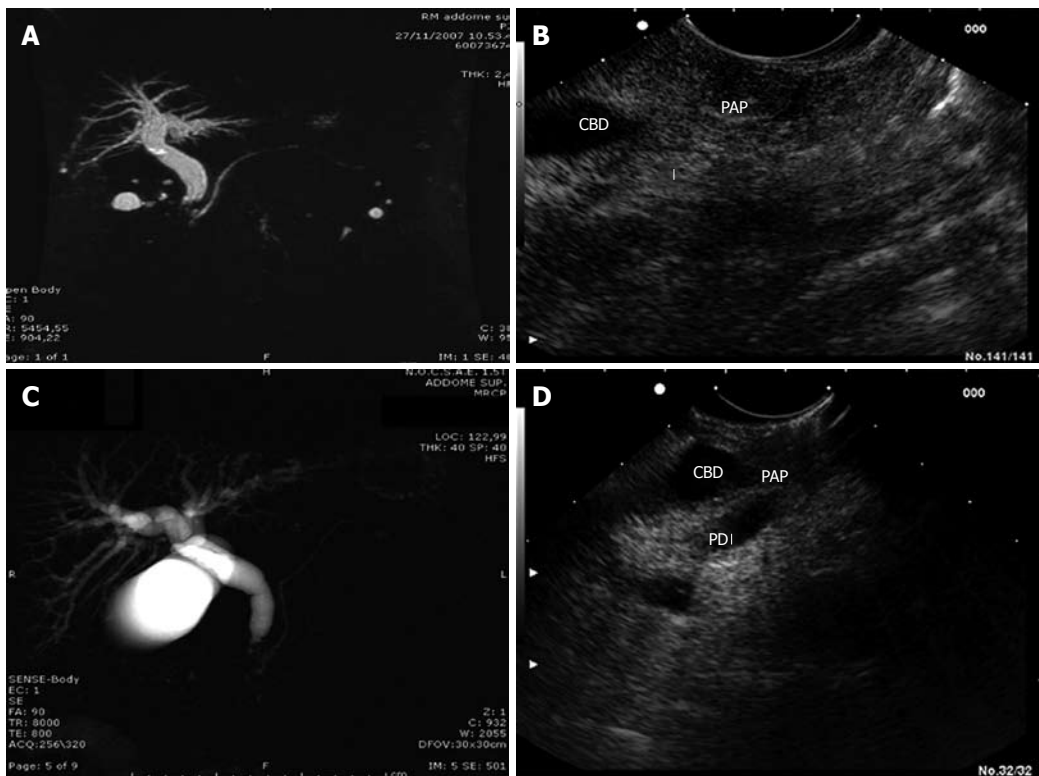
Ampullary tumor, stage 1. A: Magnetic resonance imaging (MRI) showed dilation of the common bile duct and Wirsung's duct, without space-occupying lesions of the ampulla; B: Linear endoscopic ultrasound (L-EUS) of the same patient. Ampullary tumor, stage 2; C: MRI showed dilation of the common bile duct and normal appearance of Wirsung's duct; D: L-EUS scan of the same patient, which showed duodenal wall disruption without pancreas invasion. CBD: Common bile duct; PAP: Papilla (Vater's papilla); PD: Pancreatic duct.
